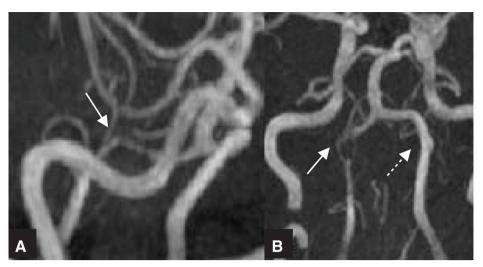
MRI on Day 26. (A) The dissecting right vertebral artery aneurysm was not visualized (solid arrow).
